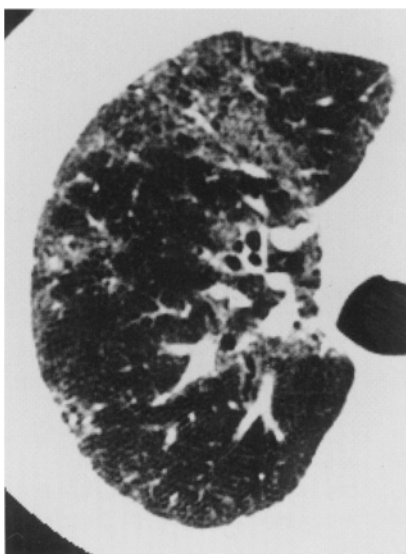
HRCT scan of aluminum pneumoconiosis. Areas of ground-glass attenuation with intralobular interstitial thickening and traction bronchiectasis is seen
